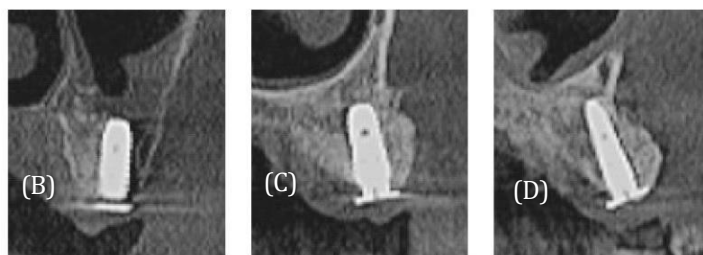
Five-month postoperative CBCT evaluation. (A) Panoramic CBCT image demonstrating stable vertical ridge reconstruction following application of the Tent Pole System and new bone formation with bone graft-free sinus augmentation. (B–D) Cross-sectional CBCT images confirming maintenance of the regenerated three-dimensional ridge contour around the implants and in the implant-free pontic sites.
